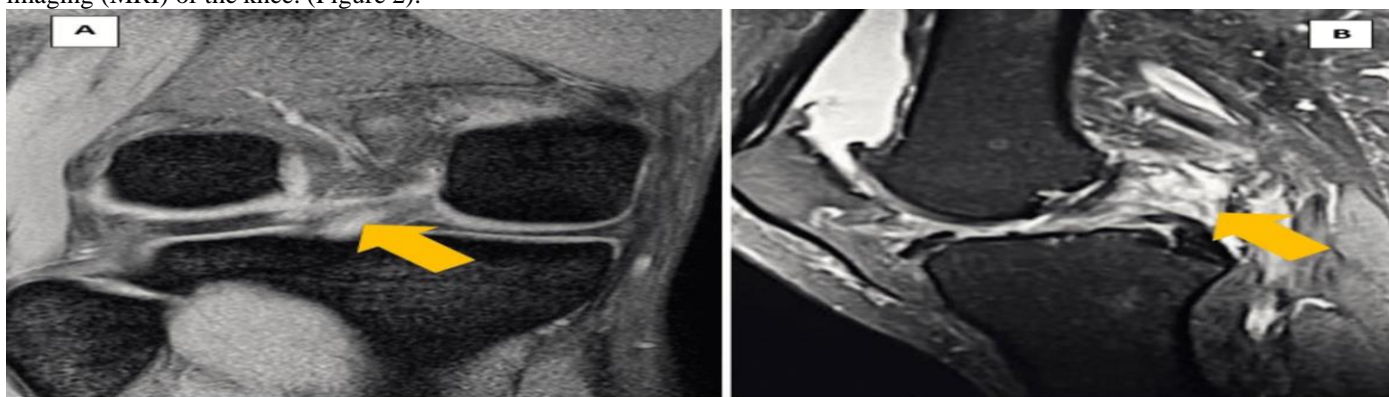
Coronal and Sagittal T2-weighted images of the lesion in the posterior cruciate ligament (PCL).
